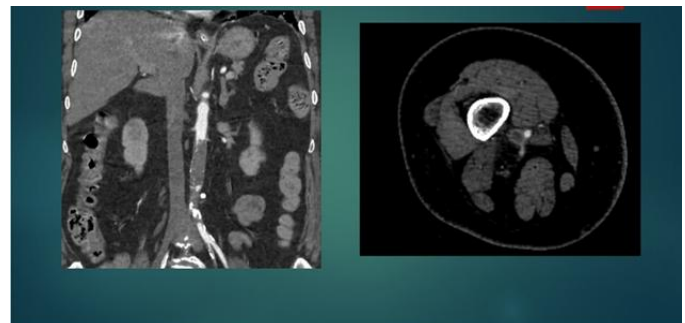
CT aortogram showing occlusion of infrarenal abdominal aorta
